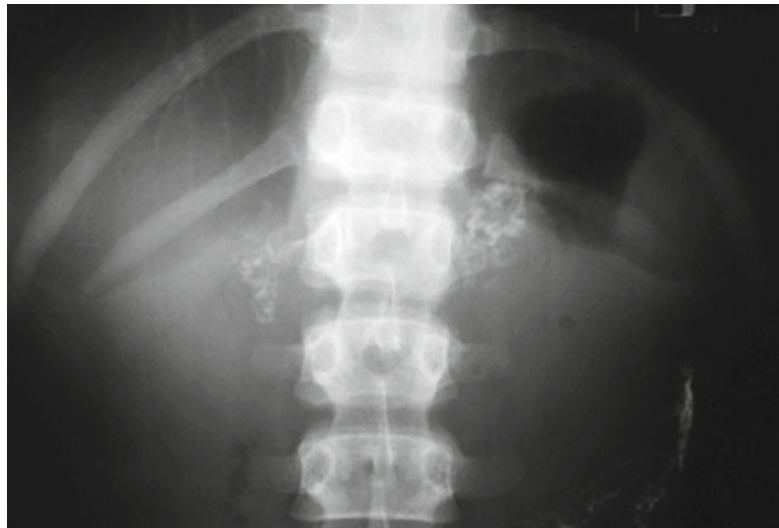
Wolman disease. Abdominal radiograph in a 6-month-old boy reveals calcifications outlining the enlarged adrenal glands, findings typical of Wolman disease
